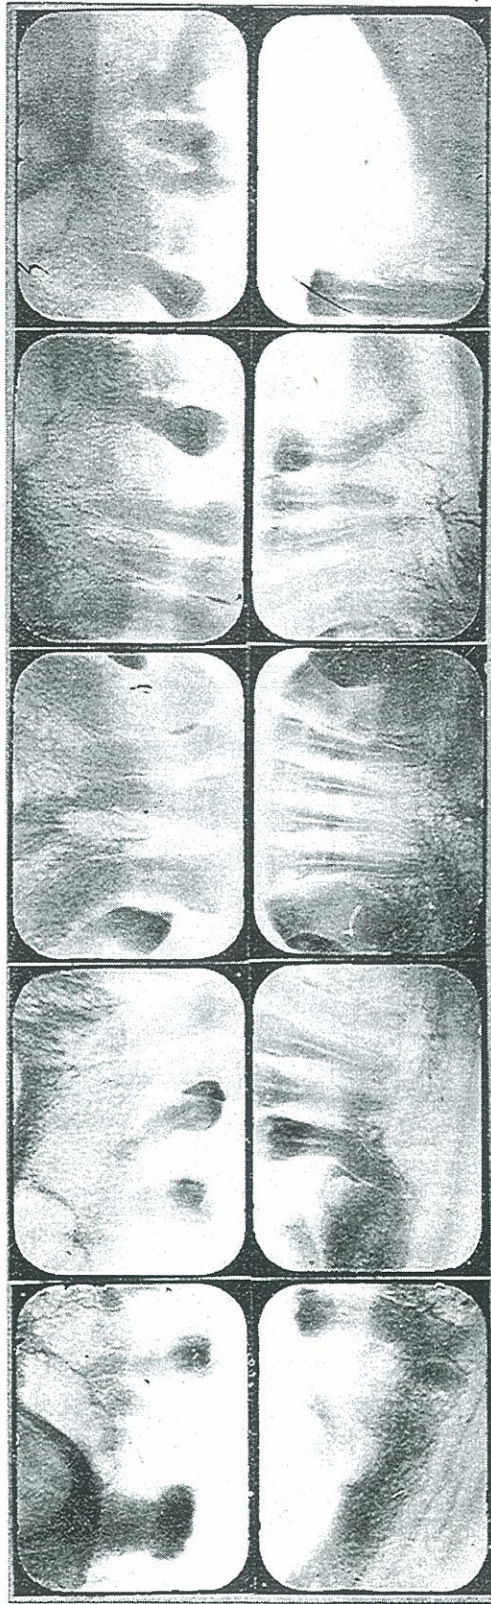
ROENTGENOGRAPHIC APPEARANCE OF TEETH OF PREVIOUS CASE. THIS PATIENT HAD THE DEGENERATIVE TYPE OF ARTHRITIS, NOT PROLIFERATIVE. NOTE DIFFERENCE IN ALVEOLAR CHANGES. AN OVERGROWN SEGMENT OF MESIAL ROOT OF LOWER LEFT FIRST MOLAR WAS UNCOVERED BY TREPHINING. THE BONE CHANGES ARE SHOWN IN NEXT FIGURE.
